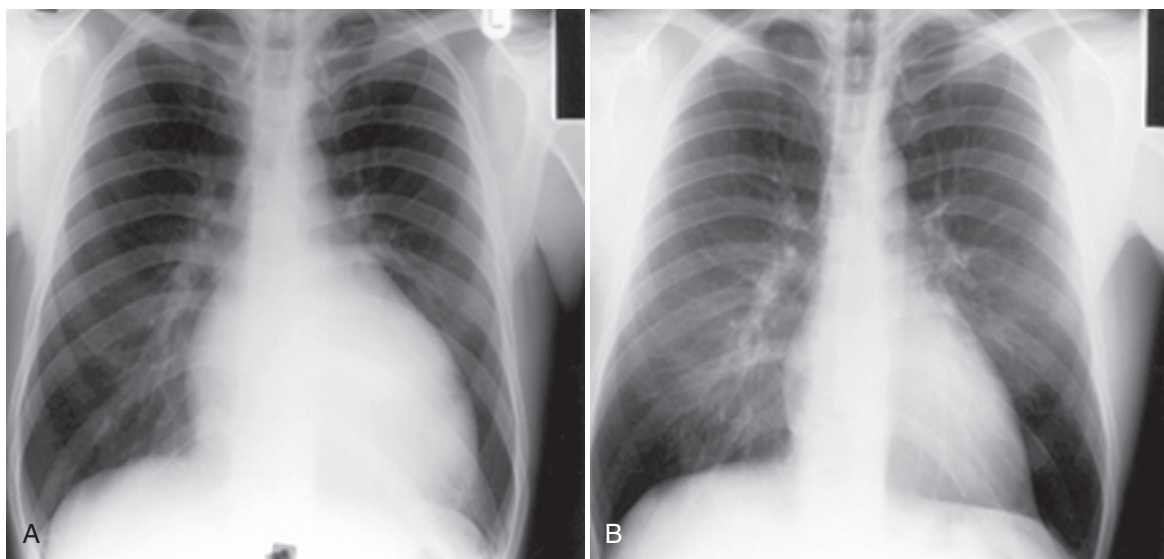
Reversal of cardiac enlargement on chest radiographs 3 months after restoration of sinus rhythm.
